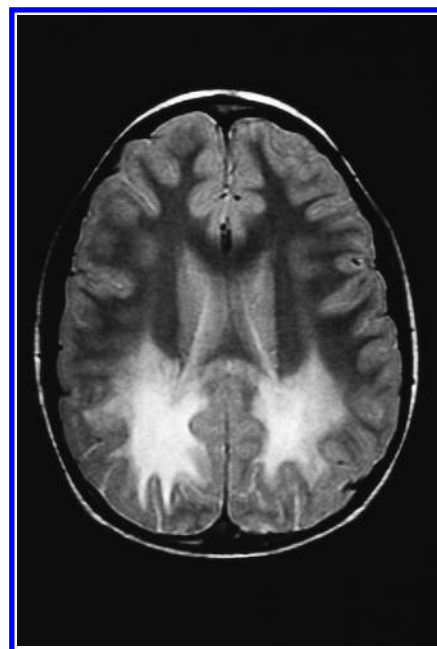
Magnetic resonance image of the brain of HM. The intense T_2 signal in the white matter was indicative of the leukodystrophy.
